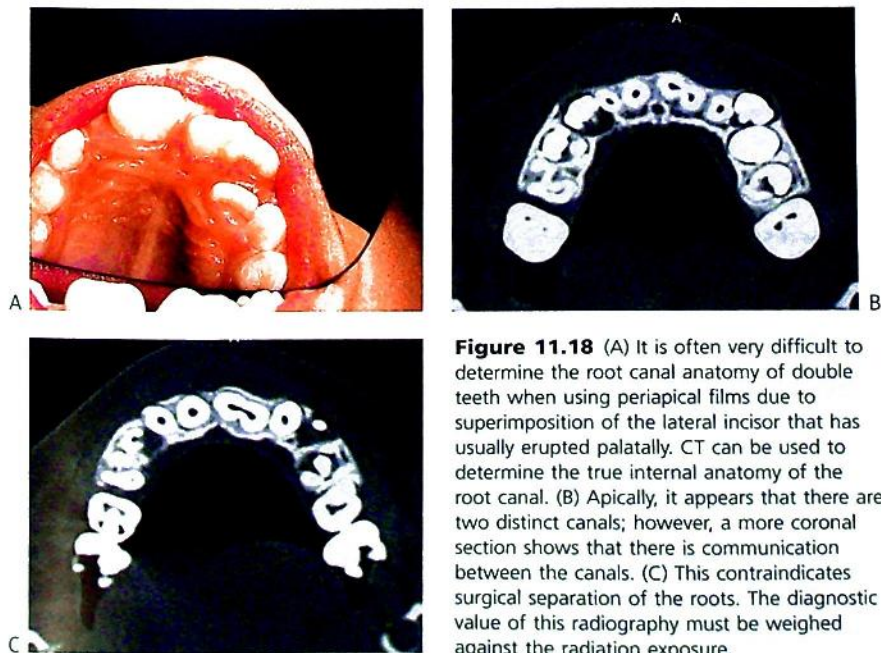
(A) It is often very difficult to determine the root canal anatomy of double teeth when using periapical films due to superimposition of the lateral incisor that has usually erupted palatally. CT can be used to determine the true internal anatomy of the root canal. (B) Apically, it appears that there are two distinct canals; however, a more coronal section shows that there is communication between the canals. (C) This contraindicates surgical separation of the roots. The diagnostic value of this radiography must be weighed against the radiation exposure.
